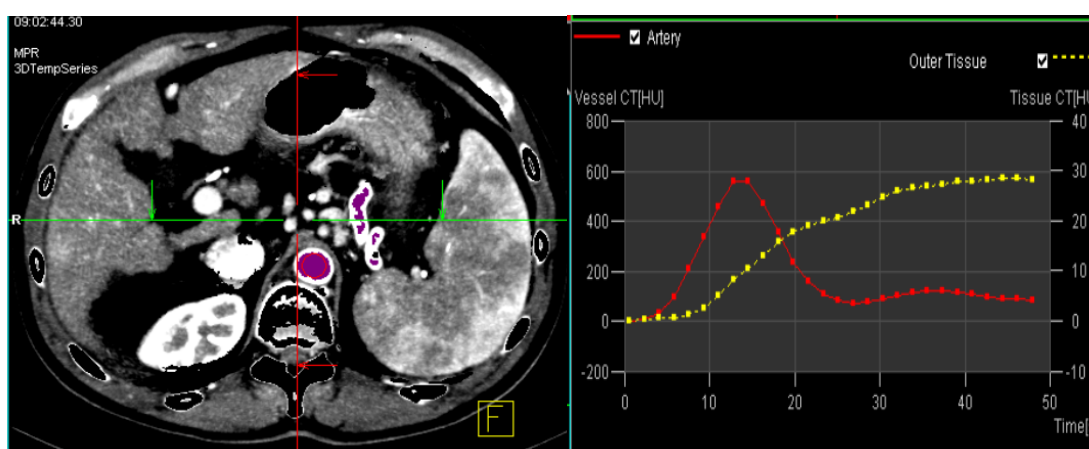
A liver perfusion CT image (left) and the graph (right) obtained. The red line represents arterial enhancement (obtained from placing the marker of the region of interest on the aorta, as shown on the CT image on the left), while yellow line represents the portal enhancement obtained from placing the marker on the portal vein (not shown on this CT image).
